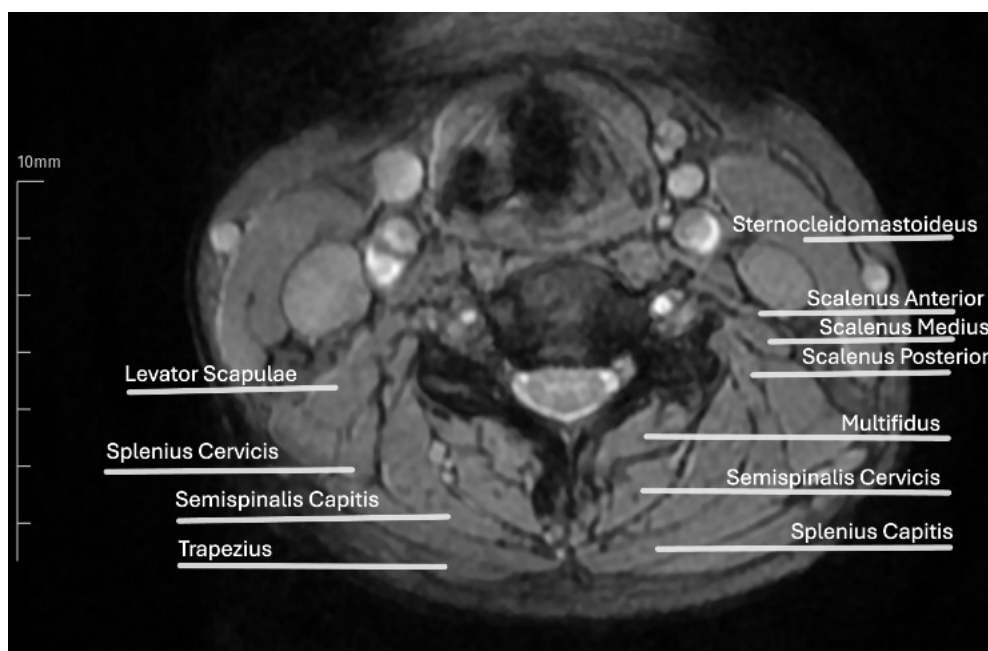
A measurement trace around the cross-sectional areas of the paraspinal muscles at the C4-5 level of Magnetic Resonance Imaging slice using ImageJ 1.53 software program (produced by Wayne Rasband, United States National Institutes of Health, Bethesda, MD).
